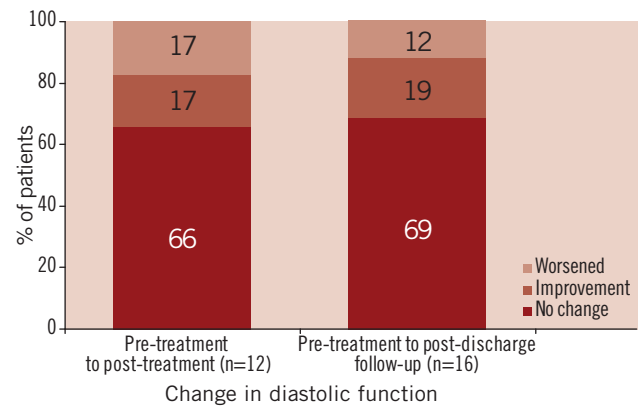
Intra-individual change in diastolic function during serial echocardiographic evaluation from pre-treatment to post-treatment and from pre-treatment to post-discharge follow-up ( $n$ =number of patient echocardiograms with sufficient information for assessment and comparison of diastolic function).
